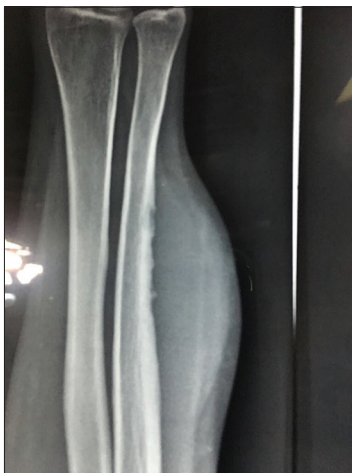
X-ray showing small multiple erosions of the ulnar shaft
